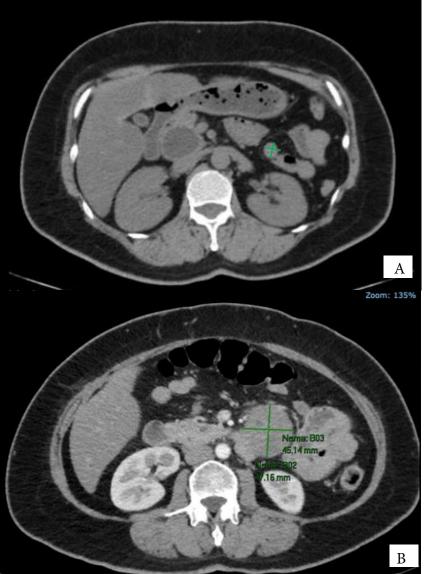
A: On dynamic pancreas scan, a 1.5×1.5 cm mass can also be visualized near the jejunal segment, consistent with the desmoid tumor's intraoperative location. B: On an intravenous contrast-enhanced abdominal CT scan, there is progression of the mass to $4.7 \times 4.5 \times 4.7$ cm with normal bowel gas pattern.
